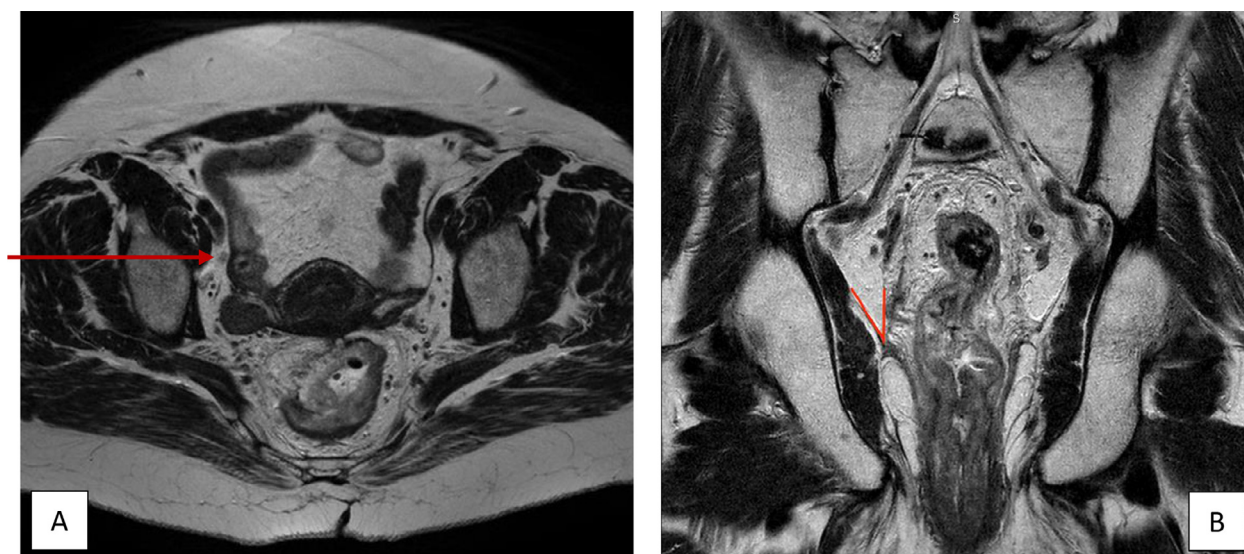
Axial (A) and coronal (B) T2 magnetic resonance images displaying sections of the obturator compartment. These two areas were often left out of irradiation delineations. (A) Axial T2-weighted slice with red arrow showing an anterior obturator lateral lymph node located just behind the external iliac vessels. (B) Coronal T2-weighted slice in which red lines denote a deep section of the obturator compartment, which extends toward the levator ani muscle. This is the section caudal of where the internal iliac artery leaves the pelvis.
